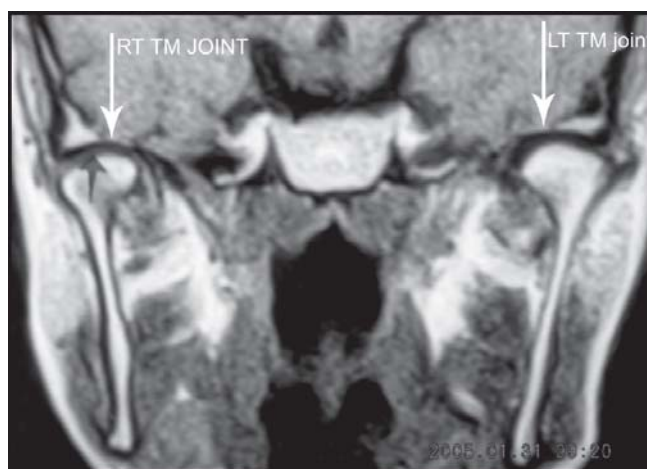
MRI of a TM joint in the coronal plane
